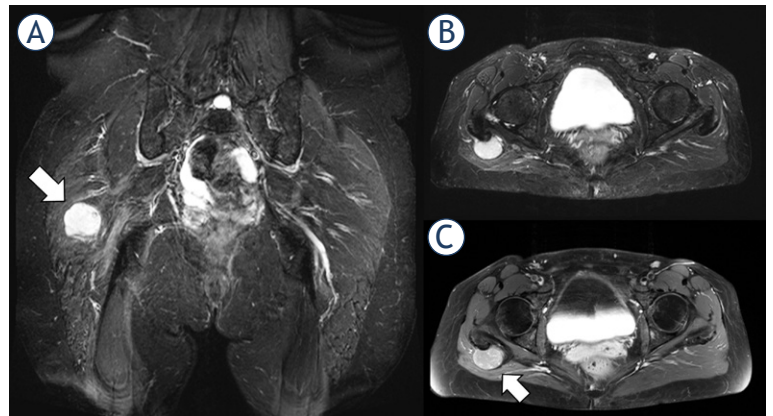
1.5-T MRI of the pelvis (A) proton density [PD] fat saturation [FS]: coronal, (B) PD FS axial, (C) contrast-enhanced T1 FS axial) of a 51-year-old patient. The low-grade sarcoma in the right gluteal region (white arrow) shows an ovoid/nodular configuration and well-defined borders.
